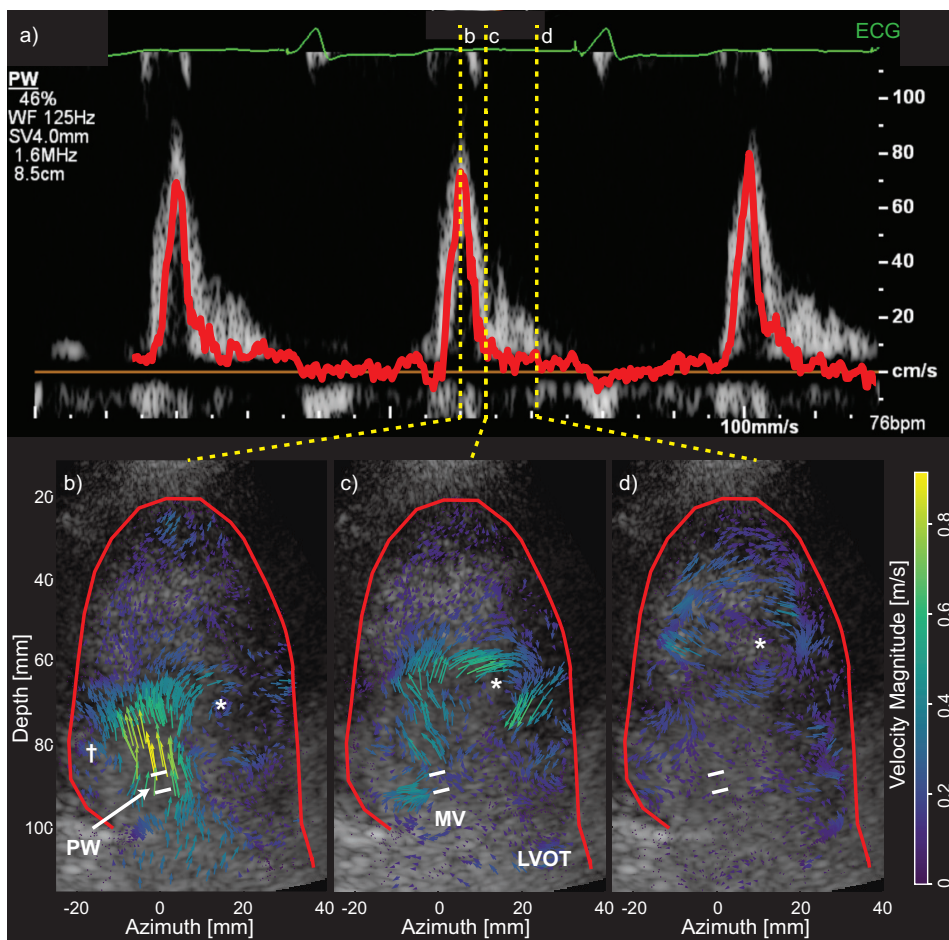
(a) Mean echoPIV velocity (red) overlaid on Pulsed-wave Doppler spectrogram obtained in the mitral valve region (see PW in (b)). (b – d) Velocity map visualization during diastolic filling (temporal locations marked in (a)), showing the high velocity trans-mitral jet entering the ventricle (b) and central clockwise vortex that starts basally and migrates apically (c – d). Supplementary Video included online. MV = Mitral valve, LVOT = left ventricular outflow tract. *Large, persistent clockwise vortex that pinches-off the jet and migrates apically. † Small, transient counter-clockwise vortex constrained by free-wall.
